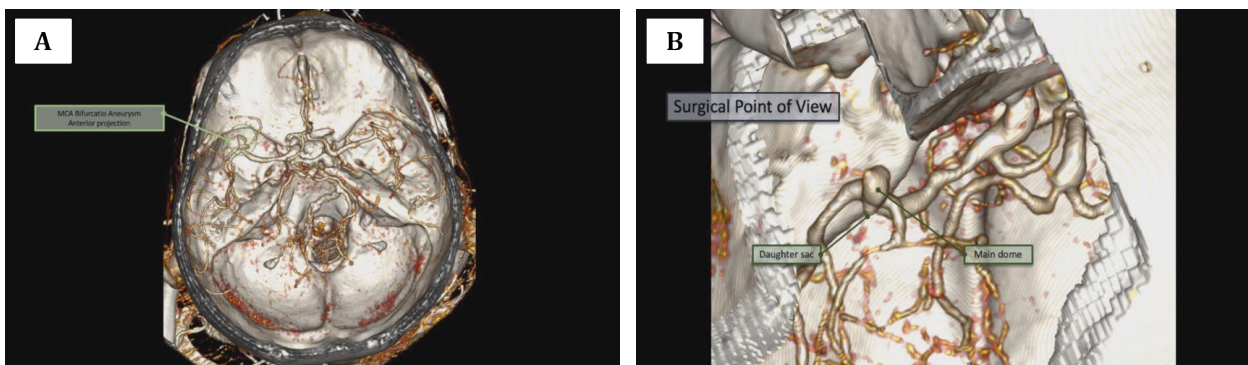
Pre-operative imaging of Computed tomography angiography (CTA) shows a saccular aneurysm on the left M1-M2 bifurcation artery.
